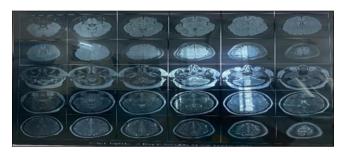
MRI brain and orbit with venogram
